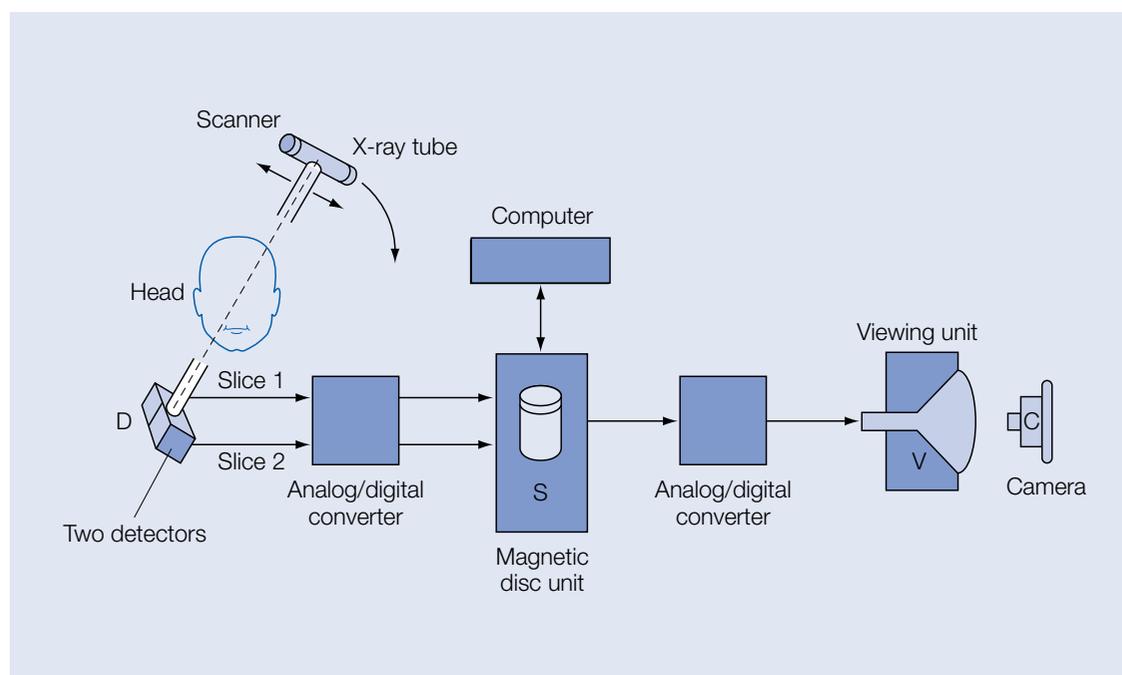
Principle of operation of the EMI scanner system as described by Ommaya in this early report of computed tomography of the brain. The X-ray tube sends a beam of photons through the head that are detected on the other side by two photo-multiplier tubes. A magnetic disc unit receives their output; from this, the computer produces the processed digital information. The computer data are converted into analog format for presentation on a cathode ray oscilloscope viewing unit, where they are photographed by a Polaroid camera
